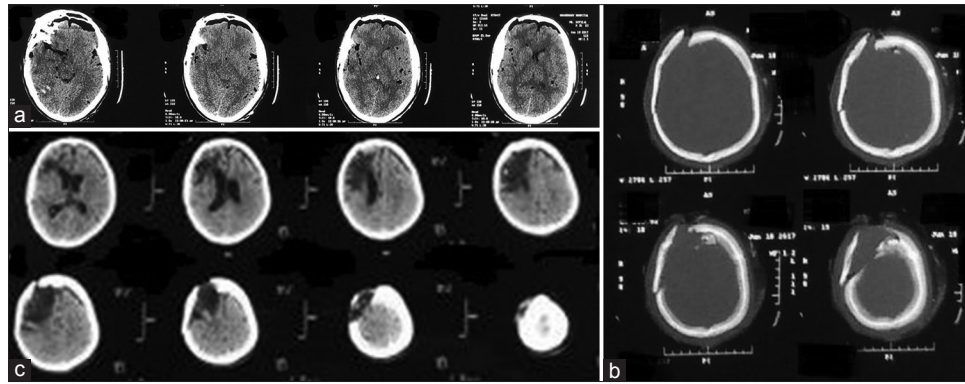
(a) Noncontrast Computed Tomography head showing right frontal bone elevated fracture with bilateral pneumocephalus, (b) Noncontrast Computed Tomography Head bone window showing right frontal bone elevated fracture, (c) postoperative Noncontrast Computed Tomography scan showing reduced fracture segment
